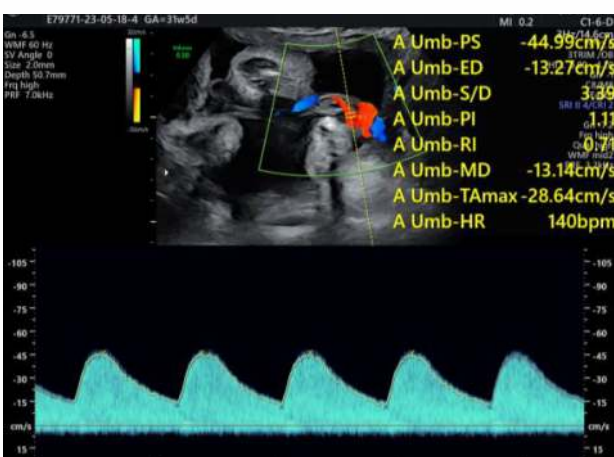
Umbilical Artery Doppler
